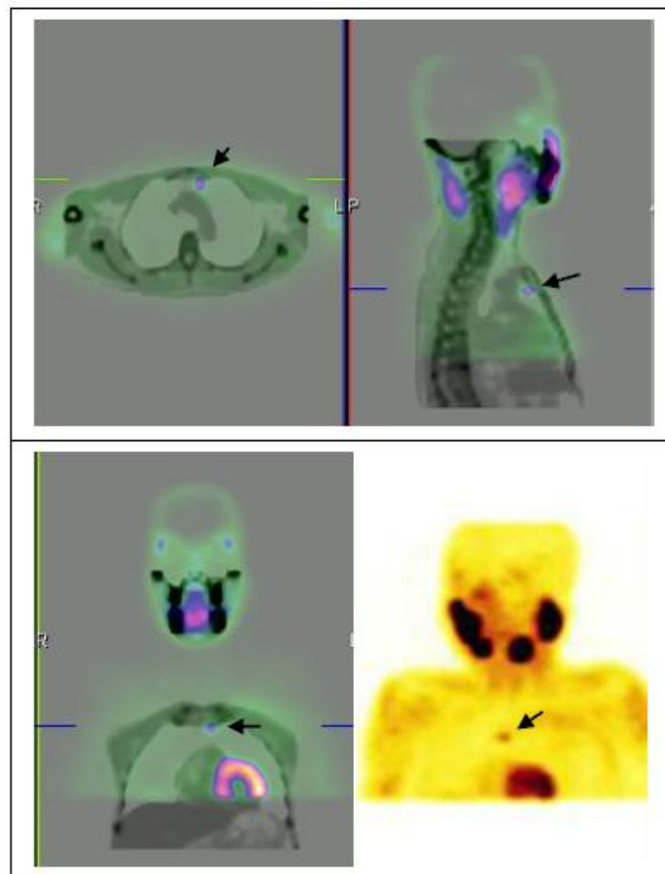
SPECT-CT image of neck and upper thorax shows focal area of increased radiotracer concentration within the anterior mediastinum at the level of D3-D4.
